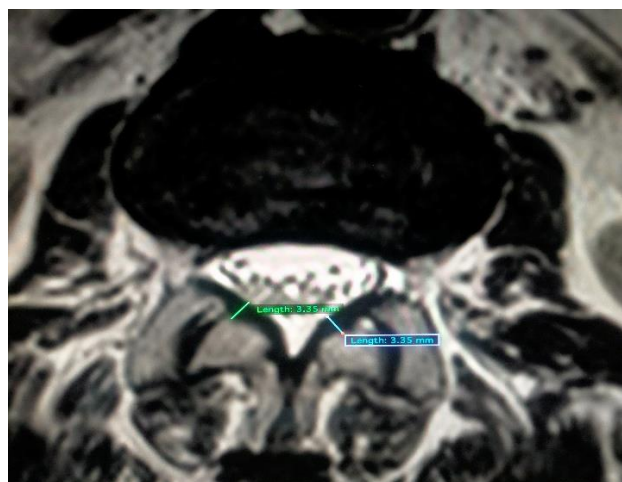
LF thickness measurement in T2W MRI at L1-L2 level.
